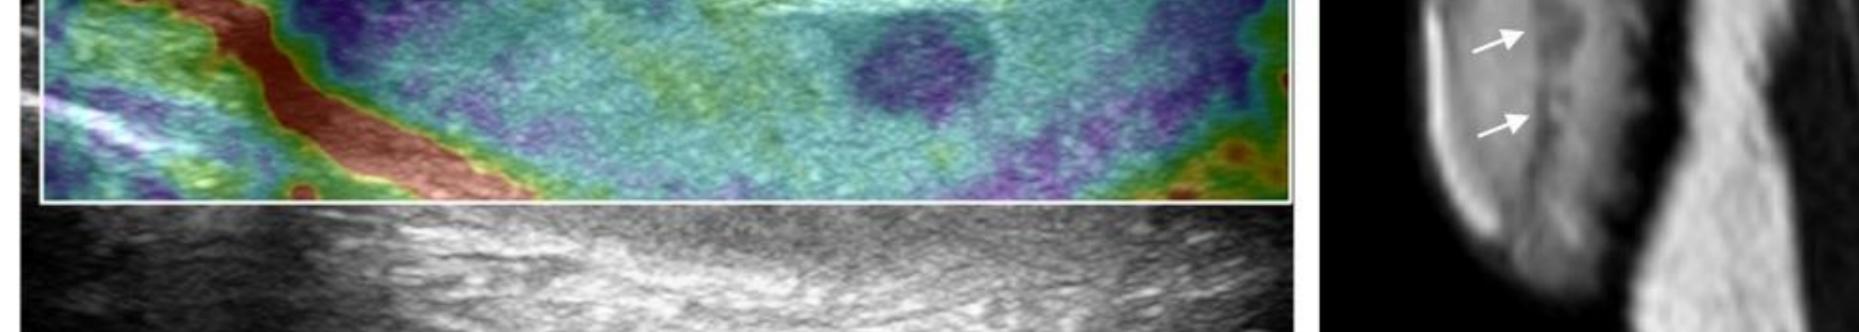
Ultrasound and Magnetic resonance imaging of TART
